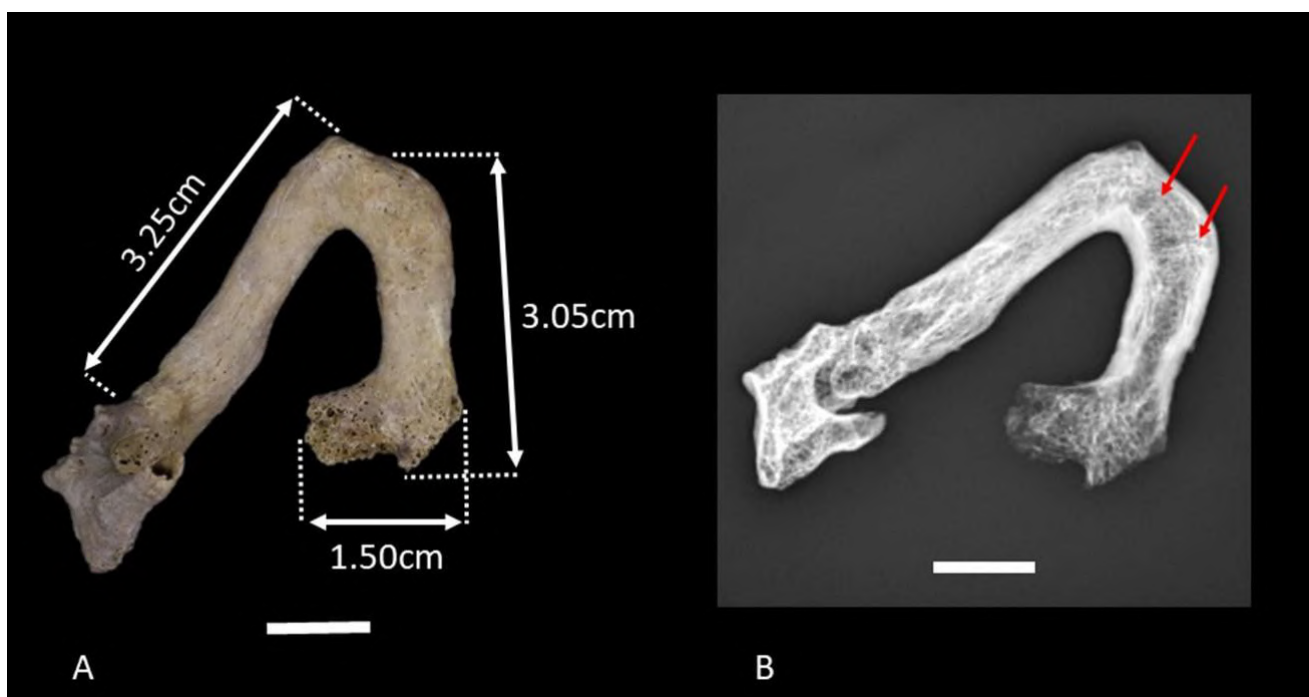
a) Measurements of the hyoid, b) X-ray image of the hyoid of the continuity of cancellous bone and two transverse lines (arrows).
